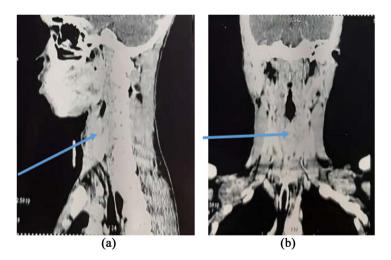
Cervical CT in sagittal sections (a) and coronal (b) showing tracheal stenosis from C6 to T2 associated with pseudo-nodular infiltrations of the lobes of the thyroid gland.
